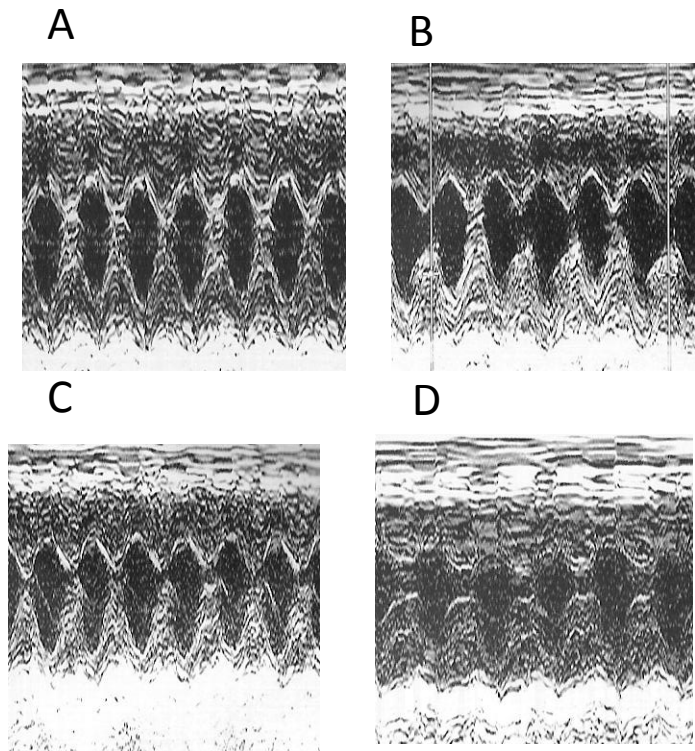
Representative m-mode echocardiography images from WT (A), WT + L-NAME (B), TG2^{-/-} (C), and TG2^{-/-} + L-NAME (D).
